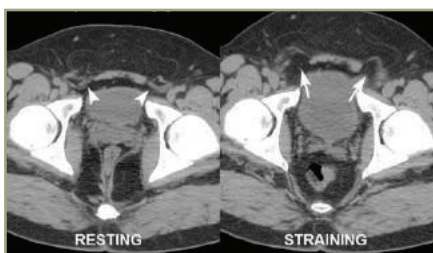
CT with Valsalva (abdominal straining) better shows bilateral direct inguinal hernias (arrows).
